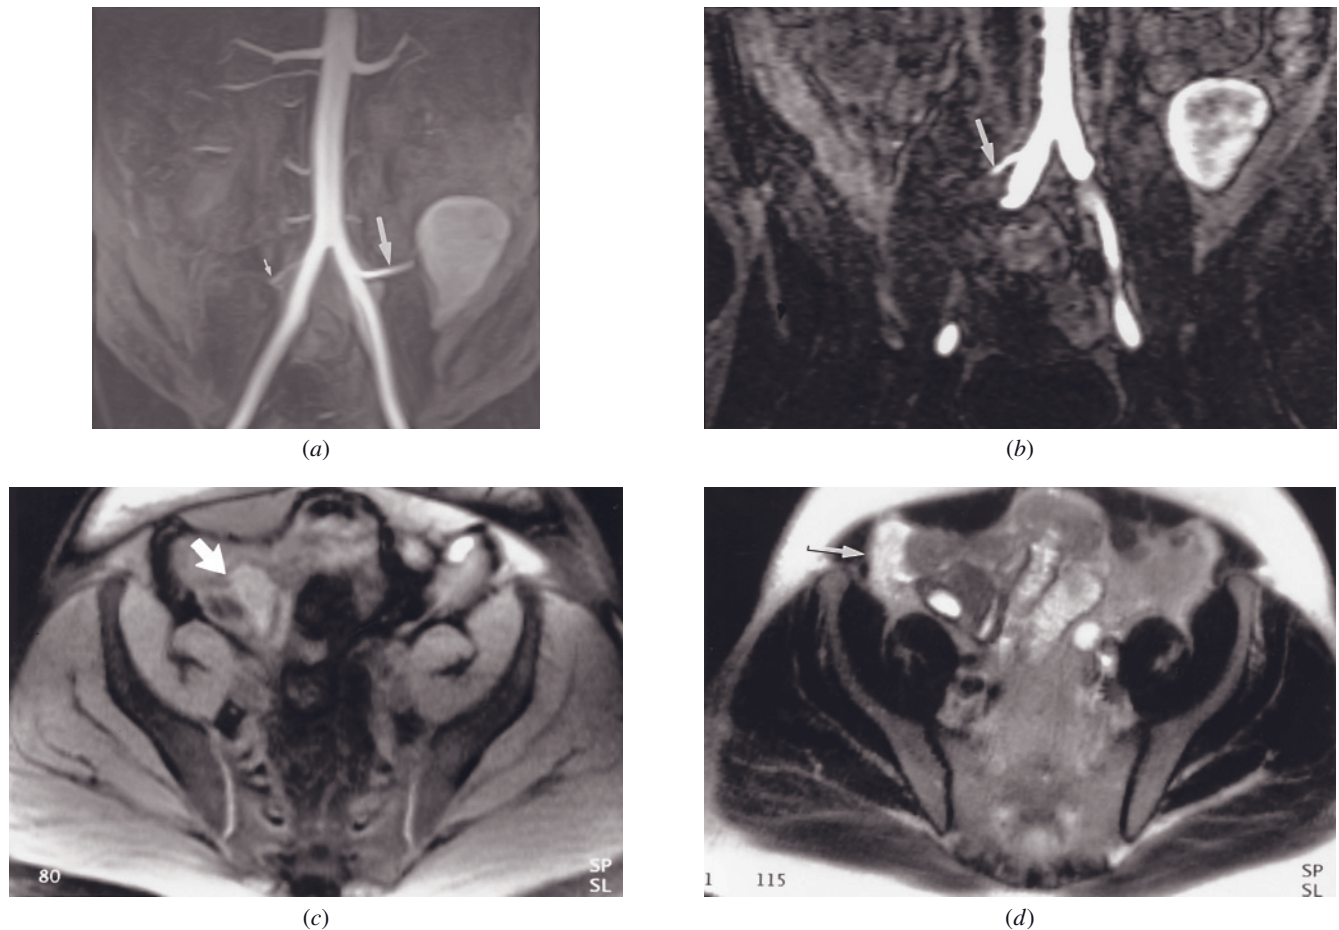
Pancreatic transplant with arterial thrombosis. Coronal MIP reconstructed MR angiography (MRA) (a), gadolinium-enhanced 2-mm 3D gradient-echo source (b), T1-weighted fat-suppressed SGE (c), and T2-weighted SS-ETSE (d) images. The MIP reconstructed MRA image demonstrates a normal artery (arrow, a) feeding the renal transplant in the left pelvis and an occluded artery (small arrow, a) feeding the pancreas transplant in the right pelvis. To establish the diagnosis of occlusion, examination of the source images is essential; occlusion is confirmed on the source image (arrow, b) as abrupt termination of the contrast-enhanced vascular lumen. The transplant is identified in the right side of the pelvis on T1-weighted (arrow, c) and T2-weighted (d) images. Inflammatory fluid (arrow, d) is noted adjacent to the pancreas transplant.
